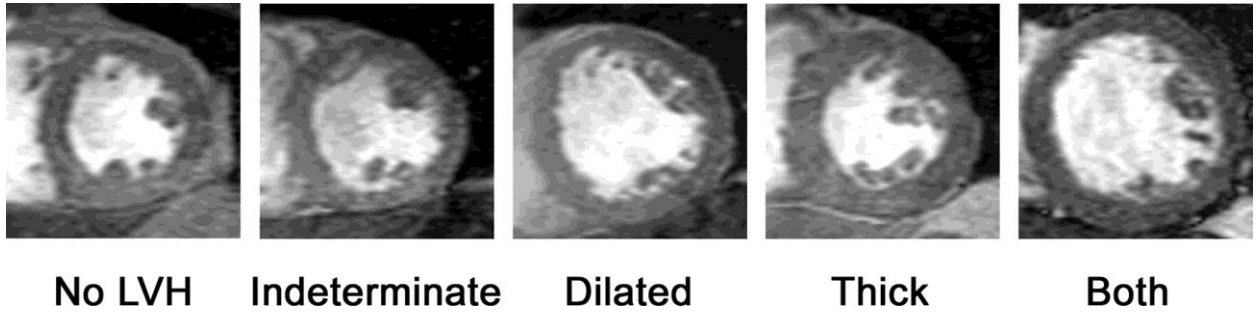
Magnetic Resonance Imaging (MRI) images of different patterns of left ventricular hypertrophy (LVH) compared to a patient without LVH²⁹.
